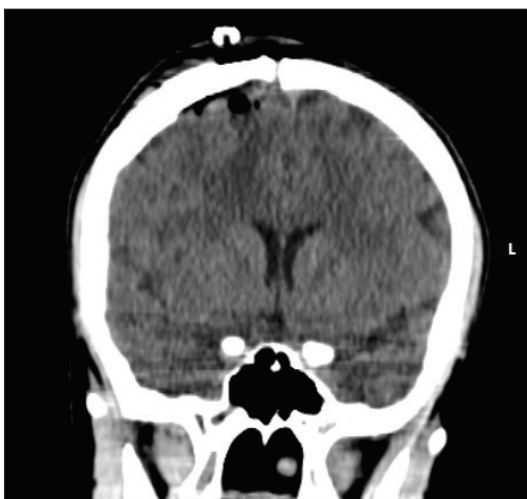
Suitable frontal lesion biopsied. Early post-operative CT-scan.
